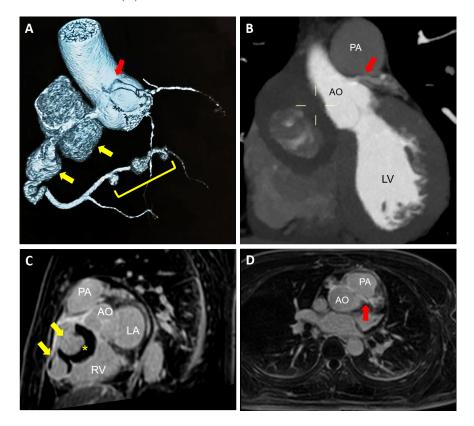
Coronary computed tomographic angiography showed two adjacent giant CAAs (yellow arrows) in proximal and middle part of RCA, and multiple CAAs in the distal part (yellow rectangle) (A). The left coronary artery (red arrow) originated from aortic sinotubular junction (B). Cardiac magnetic resonance imaging found thrombus (yellow asterisk) in those CAAs (C), and part of left main trunk (red arrow) distributing between the aorta and the main pulmonary artery (D).
